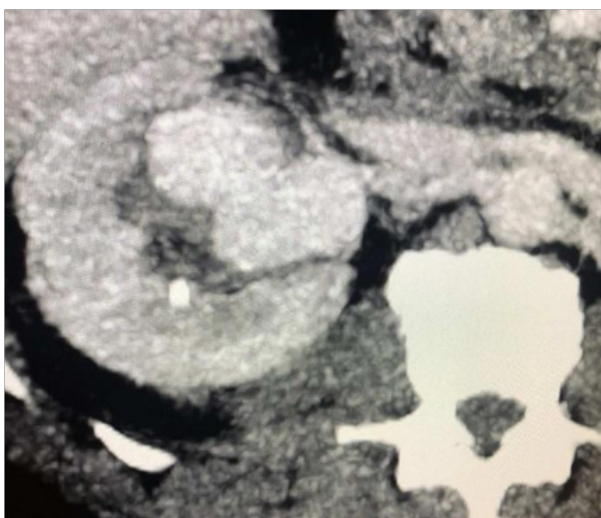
Computed Tomography of the Abdomen and Pelvis with Contrast (Axial View).
